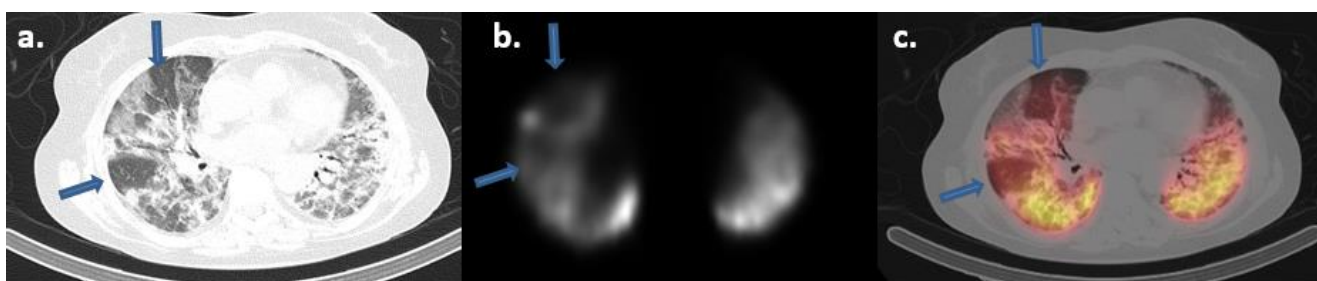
SPECT/TC-Q realizado en paciente con neumonía por COVID-19, que se diagnostica de TEP. Caso realizado en el Hospital Germans Trias i Pujol
